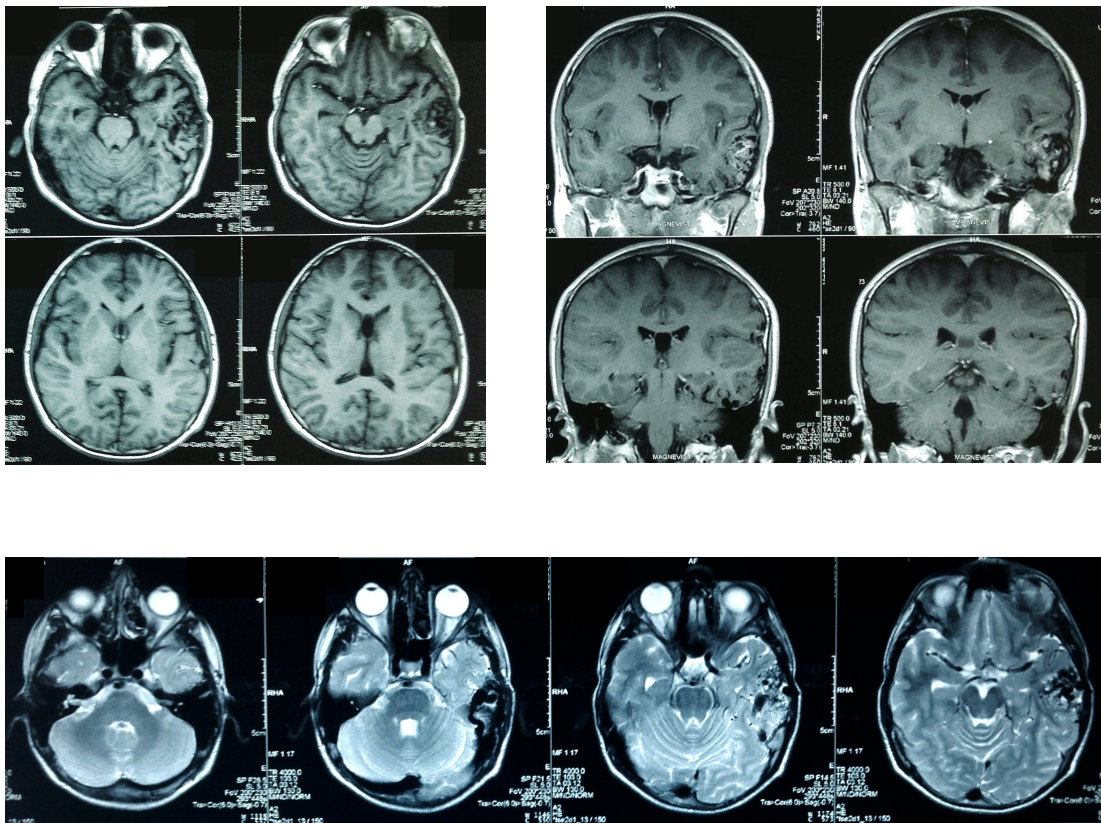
Axial and coronal views of T1WI (above) and axial view of T2WI of MRI showing vascular flow voids at the posterior left temporal region. A dilated draining vein that connects to the left sigmoid sinus can easily be seen on T2WI.
